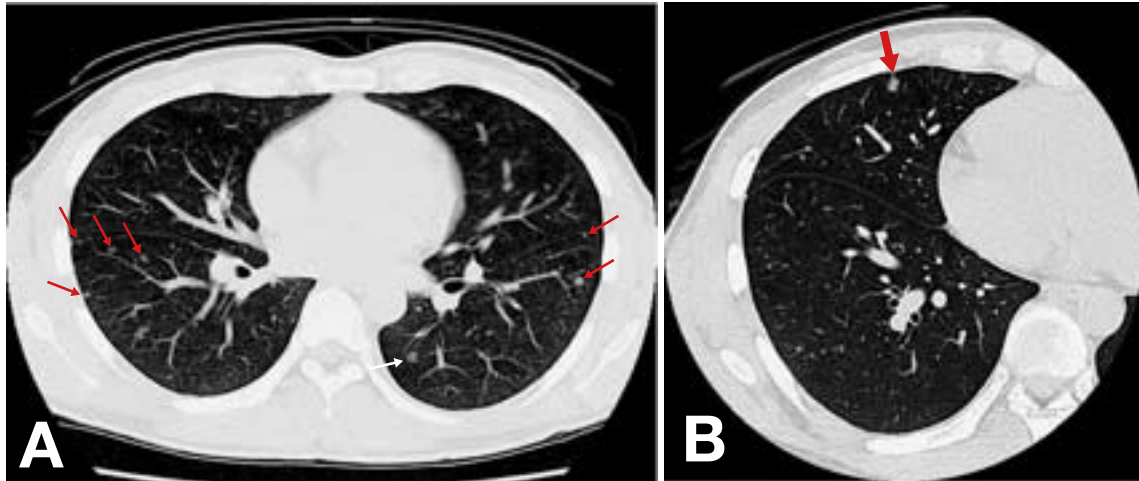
Chest computed tomographic scan reveals well-circumscribed multiple small circular nodules (arrows) in both lungs (A). They are mostly found in the lower lobe (A). A nodule with the maximum diameter of 9 mm (arrow) is observed in the right middle lobe (B).
